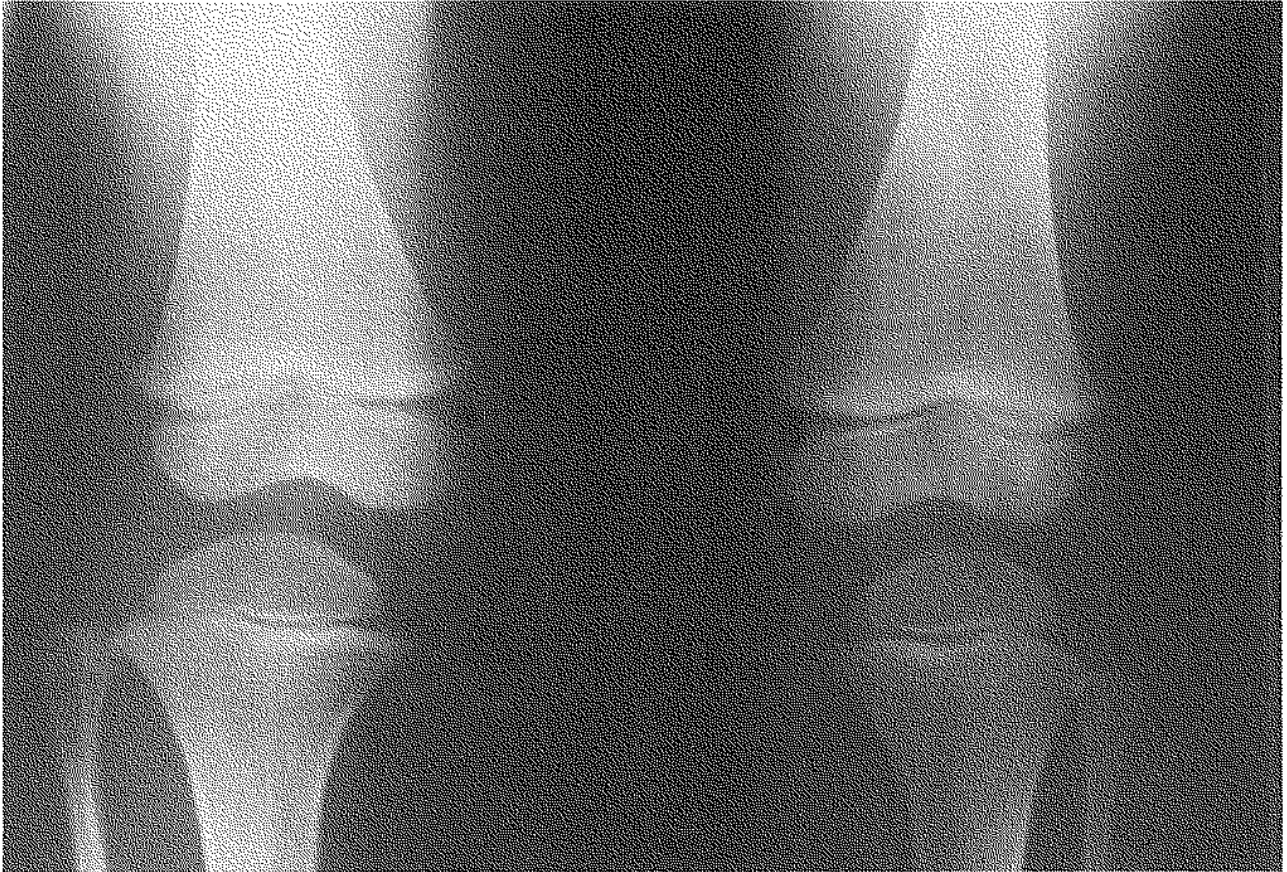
A.P. radiographs of both knees at age 3 years.
